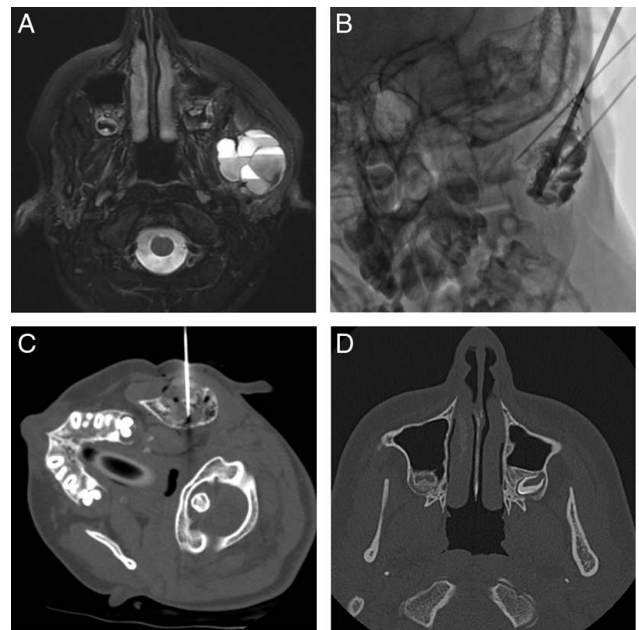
Case 1: 11-year-old girl with a left mandibular ABC. (A) Axial T2W MR image shows a multilocular lesion with multiple internal blood/fluid levels. (B) Oblique fluoroscopic image during biopsy and doxycycline injection. (C) Axial CT image from the third treatment shows needle injecting doxycycline. (D) Axial CT image at 4-year follow-up showing complete resolution of the ABC with minimal broadening of the left hemi-mandible. ABC indicates aneurysmal bone cyst; CT, computed tomography; MR, magnetic resonance.
